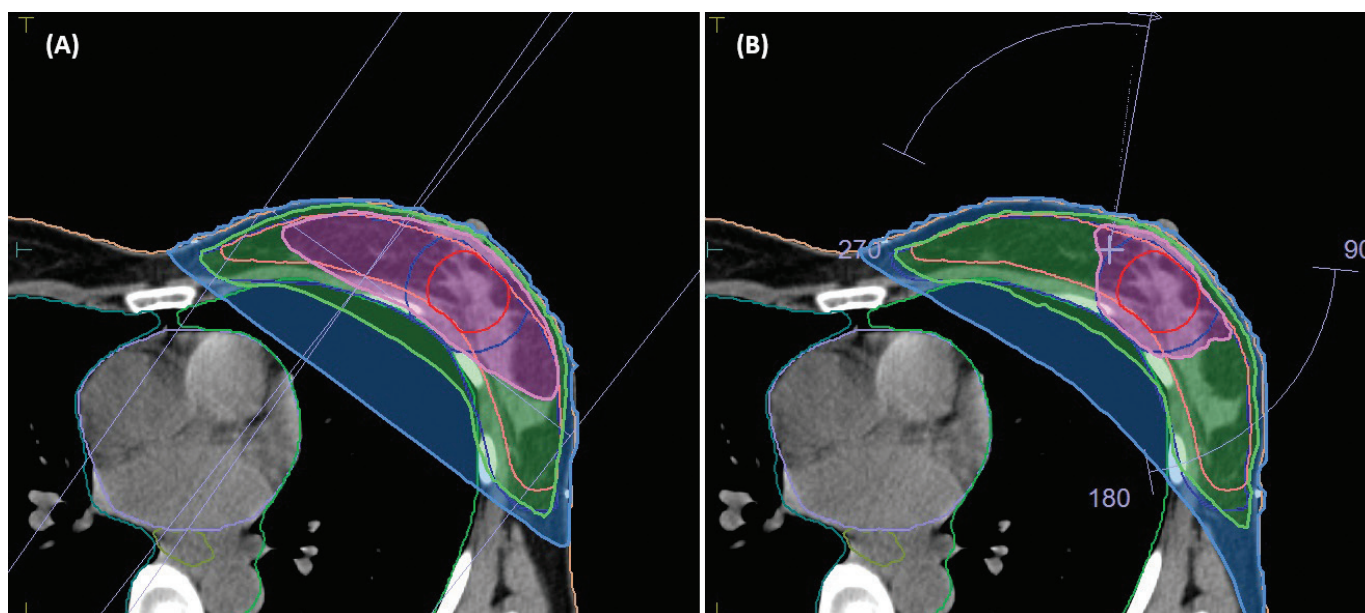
Dose distributions superimposed on a computed tomography (CT) slice shown in transversal view for treatment plans with 3D-CRT (A) and VMAT (B) technique. Dose levels shown are the 95% of the prescribed dose to the boost volume (pink area) and 95% of the prescribed dose to the breast volume (green area). The blue area represents the 20.025 Gy isodose level. The field arrangements used for the 3D-CRT and the VMAT plan are also shown. 3D-CRT: three-dimensional conformal radiotherapy; VMAT: volumetric modulated arc therapy.
